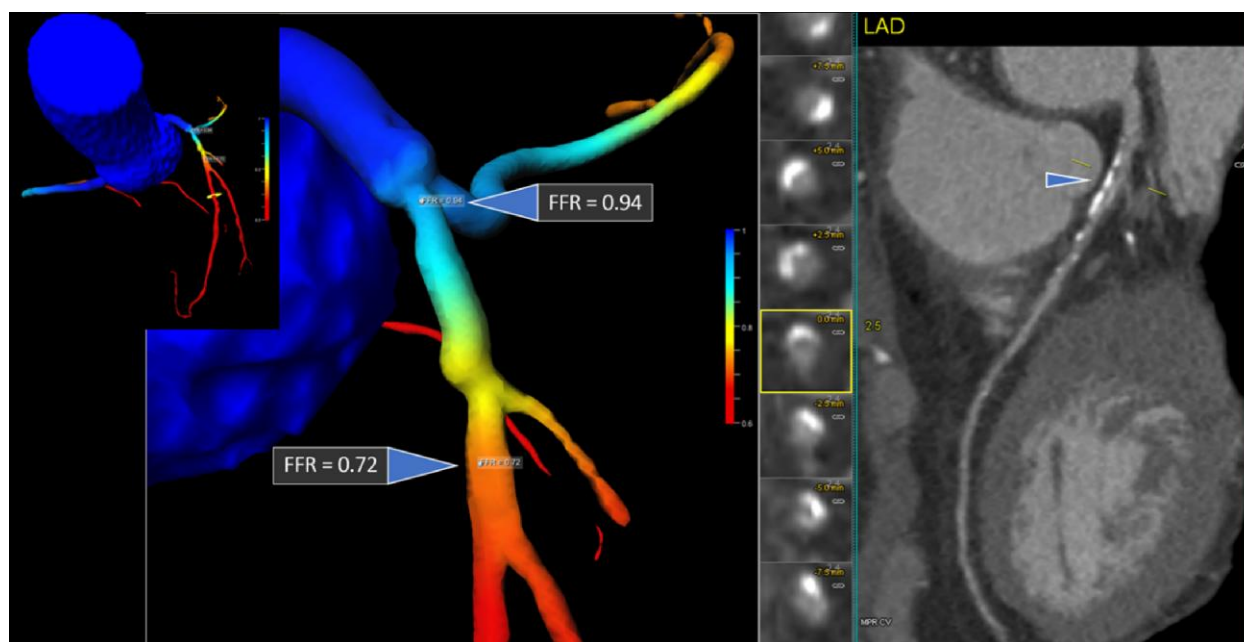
CT-FFR analysis on a patient with a severe stenosis in the proximal LAD (see CCTA, right panel). CT-FFR (left panel) shows functional significance with a CT-FFR drop to 0.72 (<0.75 is considered significant) using AI-based prototype from Siemens Healthineers (not intended for clinical use).
